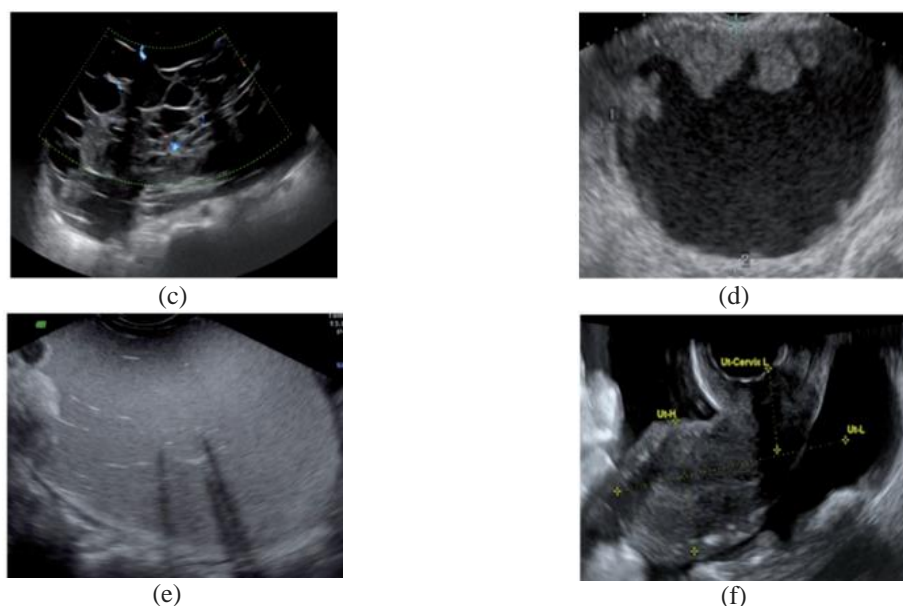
19: Ultrasound image characteristics chosen as predictors for ADNEX model (Van Calster, Van Hoorde et al. 2015) (a) Maximal diameter of the lesion (mm) (b) Proportion of solid tissue (%) (c) More than 10 cyst locules (d) Number of papillary projections (0, 1, 2, 3, more than 3) (e) Acoustic shadows (yes = 1, no = 0) (f) Presence of ascites (yes = 1, no = 0)
